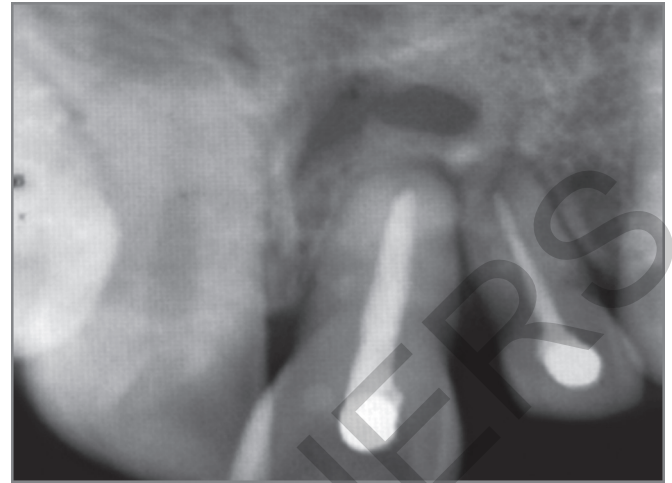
Periapical scar seen as radiolucency at the apex of central incisor.
